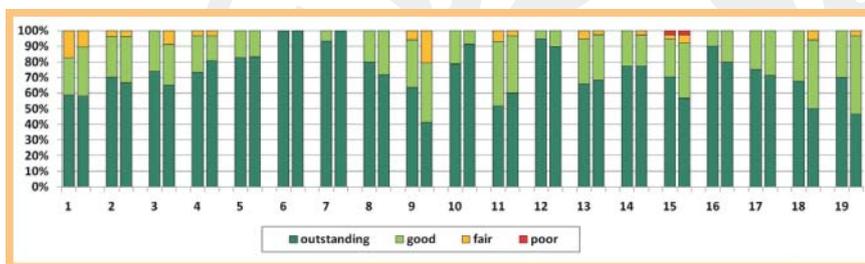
Example of an evaluation comparison of proficiency with respect to content (left bar) and didactic presentation (right bar) among the 19 tutors of an ultrasound course. The respective tutor is shown only his or her own ID number. The other 18 tutors remain anonymous for that tutor. The tutor's own position within the teaching team is still readily apparent.
